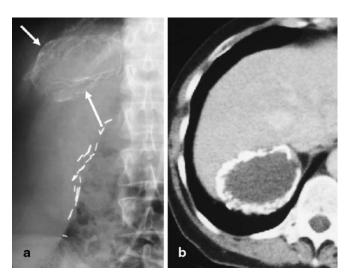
A 55-year-old female with a history of previous trauma. a Abdominal X-ray demonstrates a calcified right supra-renal mass (*arrow*). Surgical clips are secondary to previous gallbladder surgery. b Axial contrast-enhanced CT image shows a 5-cm well-defined adrenal mass with thick peripheral calcification. Enhancement could not be demonstrated within the central portion of the mass, which measures 21 Hounsfield units. The mass is unchanged during a 5-year follow-up period and is a presumed adrenal pseudocyst
